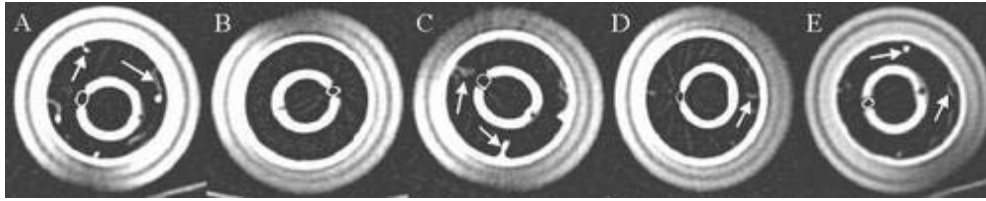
Computed tomography of the tested tubes. A Mallinckrodt HiLo. B Microcuff HVLP ICU. C Portex Profile Soft Seal. D Rüsch Super Safety Clear. E Sheridan CF. Computed tomography (spiral CT, Picker PQ 5000, Philips, DA Best, The Netherlands) was performed after bathing the tube cuffs in contrast medium (Ultravist 300, Schering, Berlin Germany), inserting them into the horizontally placed artificial PVC trachea and inflating cuffs to a pressure of 20 cmH₂O. Scan level was set at the middle of cuffs. The high contrast circumference in these scans results from bathing the cuff in contrast medium and appears in all tubes. In contrast to the Microcuff tube, the conventional tubes show additional contrast enhancement within the cuff area due to occurring folds (arrows)
